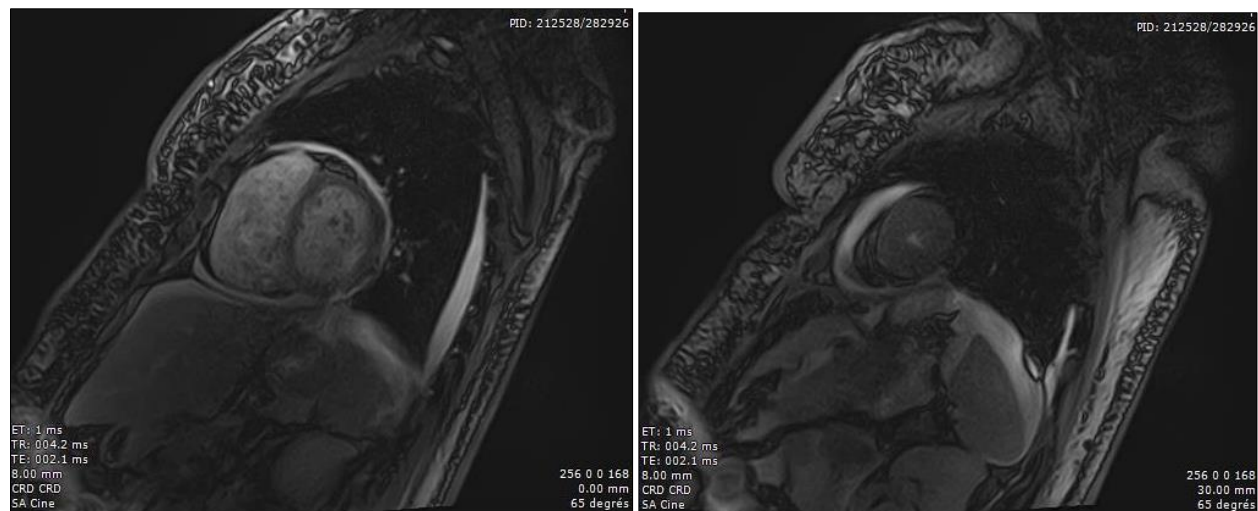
Cine-MRI (SSFP: Steady-State Free Precession), short axis at the apical and basal levels: highlighting the dilation of the right ventricle and localized hypertrophy at the apex of the left ventricle
